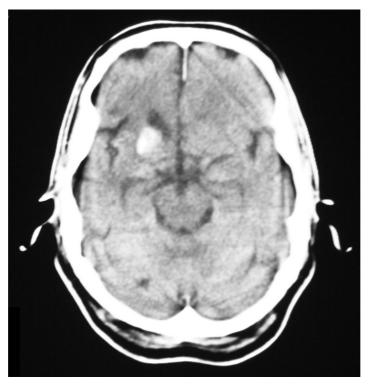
Follow up CT scan of the Brain on the 4th July 2006 showing calcification in the right Basal ganglia
